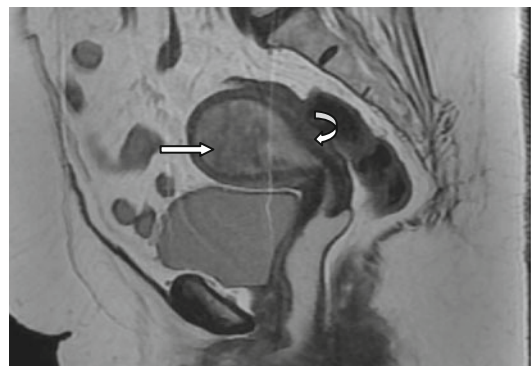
81-year-old lady with postmenopausal bleed. Sagittal T2-weighted MRI showing a large mass filling the endometrial cavity (*straight arrow*). Intact junctional zone clearly demonstrated (*curved arrow*) with no extension of mass into the myometrium. No extension to the vagina
